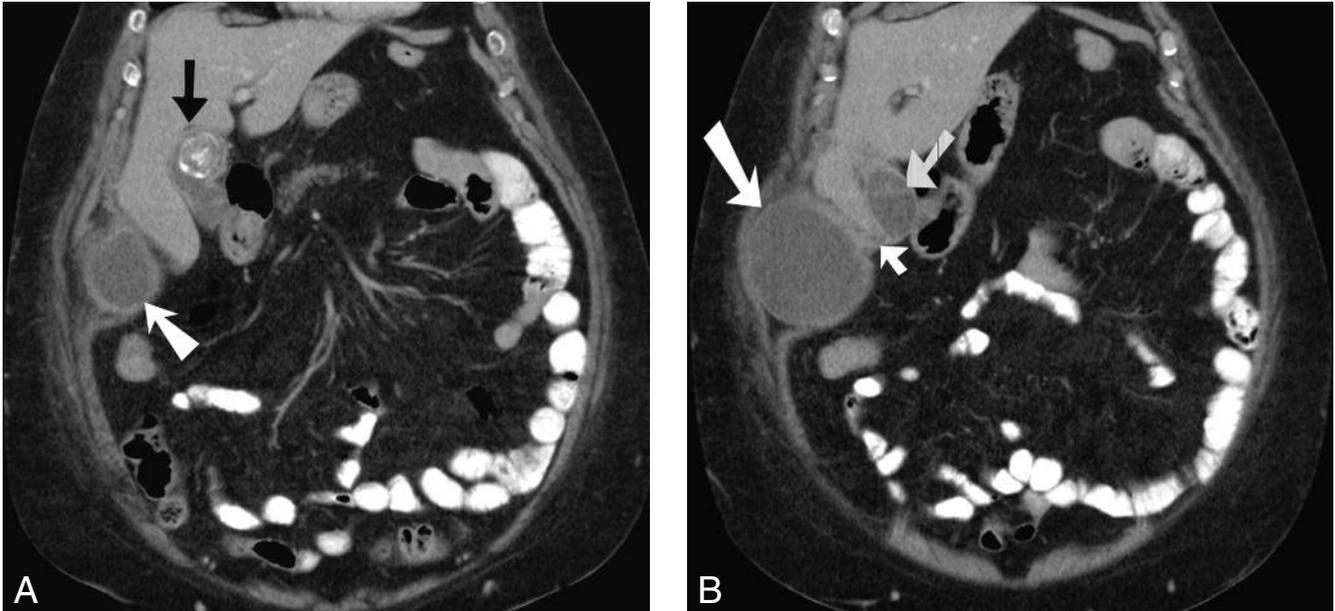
A. Coronal reformatted contrast-enhanced CT abdomen showing large laminated gallstone in the gallbladder (black arrow) and fluid collection in the right anterior abdominal wall, with enhancing rim (white arrow).
